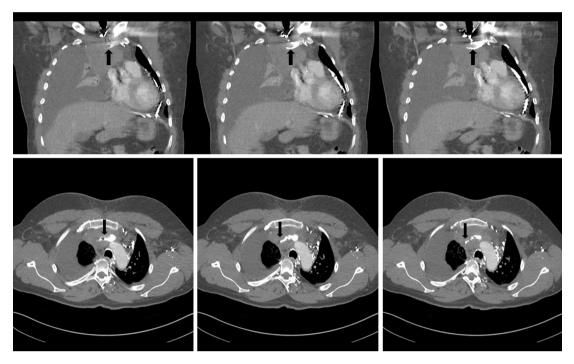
Transverse (top) and coronal (bottom) CT scan images obtained with contrast administered through a left antecubital intravenous access, showing obstruction of the SVC by a mediastinal mass (arrow).
